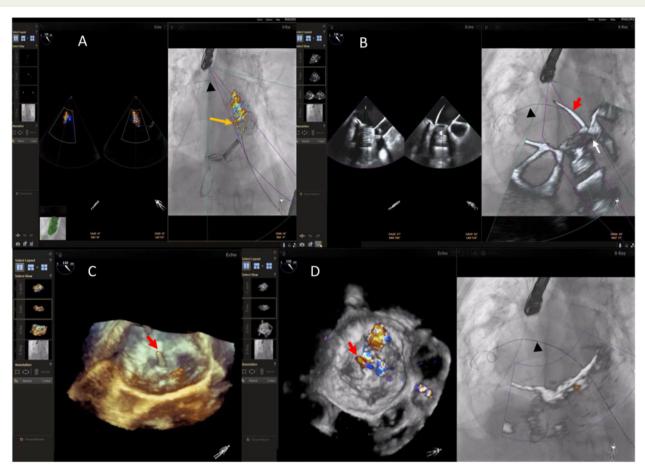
Intraprocedural fusion of fluoroscopy and real-time two-dimensional/three-dimensional transoesophageal echocardiography colour flow Doppler at 130° view showing the regurgitant paravalvular leak jet (orange arrow) (A) and the guiding catheter (red arrow) passage through the leakage (white arrow) with the fused images maintained (stiff wire in the left atrium, black arrowhead) in two-dimensional X-plain views (B); real-time three-dimensional transoesophageal echocardiography colour flow Doppler images showing the tip of the guiding catheter (red arrowhead) (C) and regurgitant jet around it (D).
